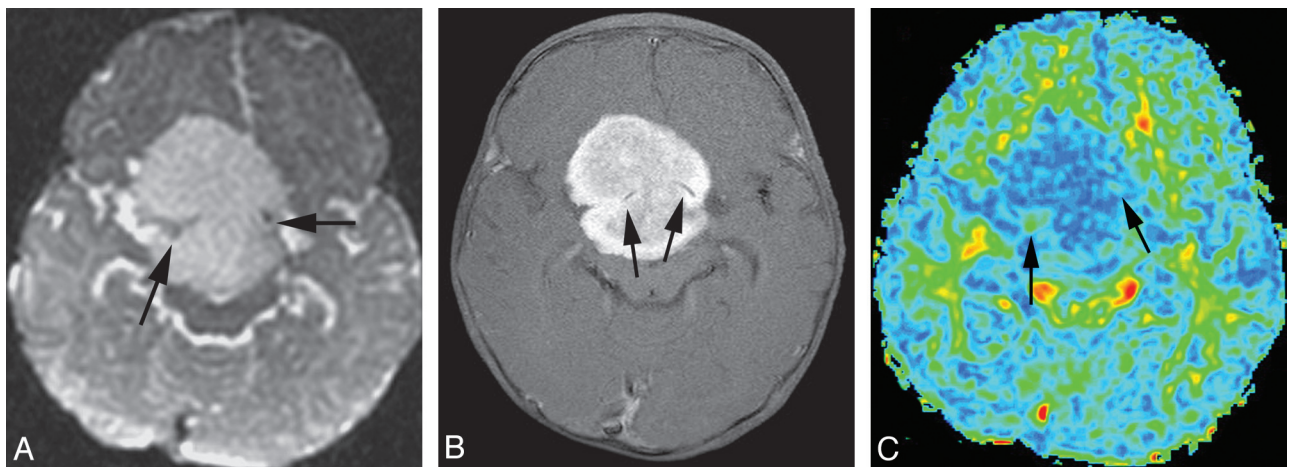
A, T2-weighted ($b = 0$) MR image shows a grade II glioma. B, Postgadolinium axial T1-weighted image shows whole-tumor contrast enhancement. C, FA map shows tumor FA with a homogeneous blue hue. The darker blue (cool color tone) represents low FA and the red and yellow (warm color tones) correspond to high FA. Region-of-interest selection for FA measurement is based on visually inspecting the hue. Maximum FA, minimum FA, FA range, and maximum SD are 0.145, 0.061, 0.084, and 0.0411, respectively. Arrows point to arteries.
